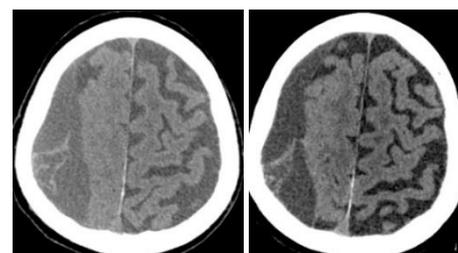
Left: Initial non-contrast CT head at presentation, showing the large right sided CSDH with significant sulcal effacement. Right: Immediate follow up non-contrast CT head, showing early reduction in the size of the CSDH with mild improvement of the sulcal effacement.
